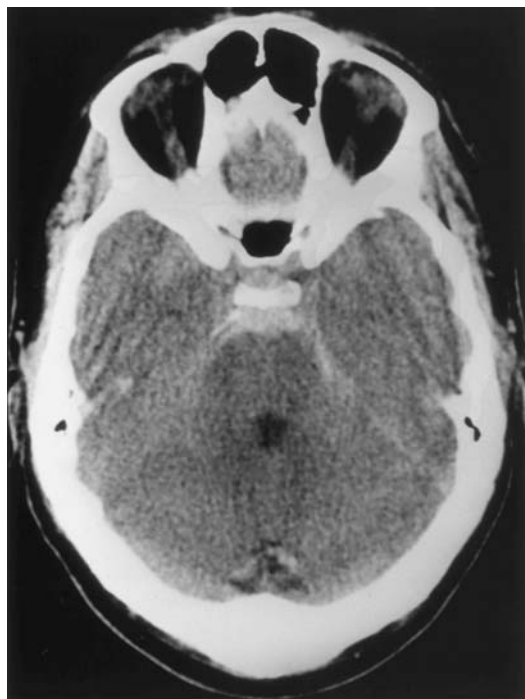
CT scan demonstrating a perimesencephalic subarachnoid hemorrhage.
